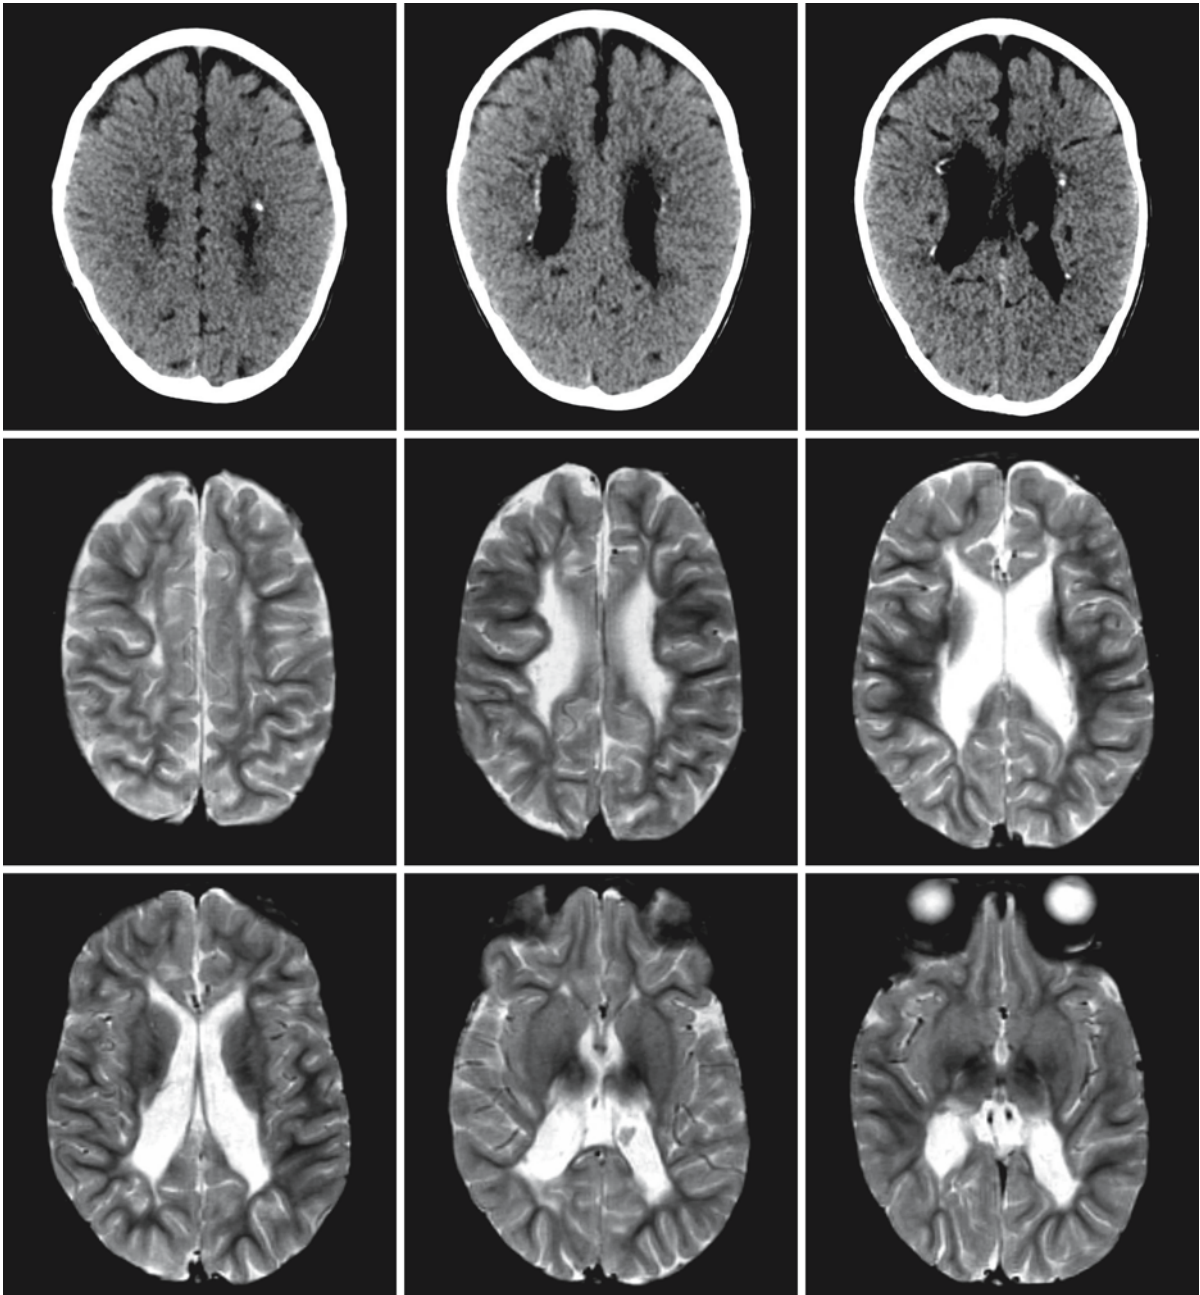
A CT scan of a girl with PVL at the age of 2 years (*first row*) shows asymmetrical ventriculomegaly and calcifications around the ventricles. The T₂-weighted MR images obtained at the age of 3 years (*second and third rows*) show severe PVL
